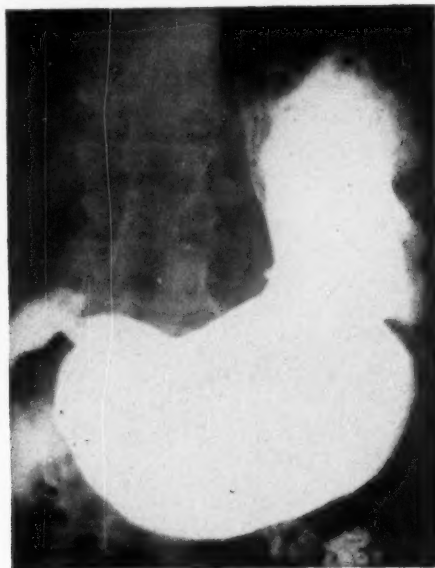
Roentgenogram of gastric ulcer seen in Fig. 1 two months later, showing only small niche and beginning incisura opposite it.
